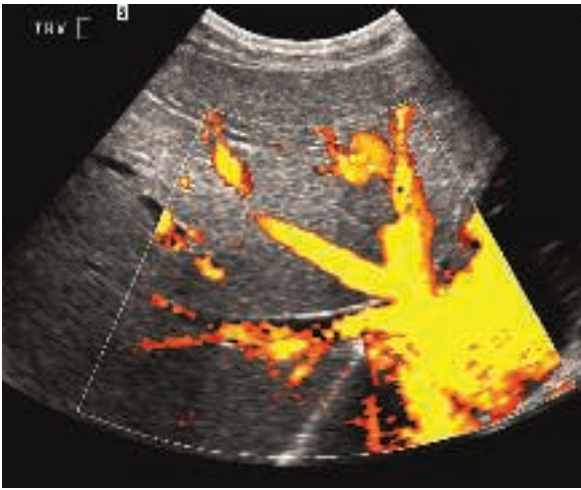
• Power Doppler of the hepatic vein confluence. Directional information is lost, but power Doppler can be superior to colour in demonstrating low velocity flow.
